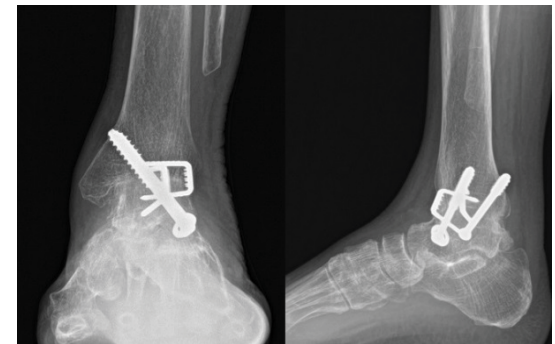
Radiographs of the ankle at Follow-up showing fusion of the ankle joint
